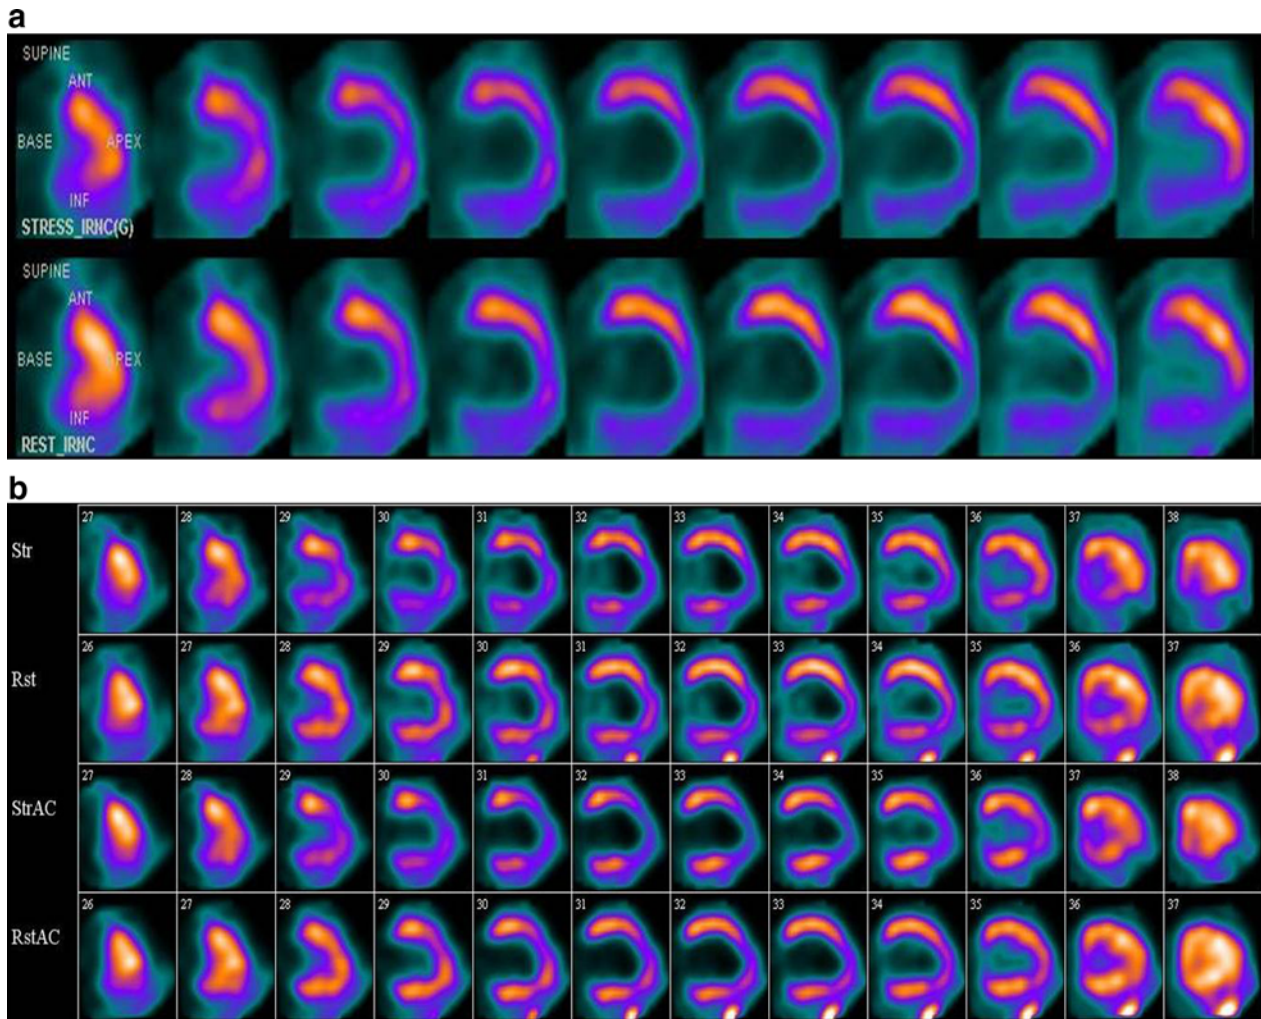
A Stress (*top row*) and rest (*bottom row*) supine SPECT was performed in this patient with an ischemic cardiomyopathy using a conventional dual-head NaI detector. In these vertical long axis tomograms the ventricle is markedly dilated, and there appear to be extensive, fixed perfusion abnormalities involving the apex and inferior wall. B The stress and rest (first and second rows, respectively) acquisitions were repeated on the Digirad X-ACT[®] camera with the patient sitting upright. There is partial resolution of the fixed inferior defect, indicating that with supine SPECT it was at least in part attributable to diaphragmatic attenuation. With additional AC (*third and fourth rows*) there is complete resolution of the inferior defect, indicating that with supine SPECT it was entirely attributable to diaphragmatic attenuation. There is also partial resolution of the resting apical defect, indicating some degree of stress-induced ischemia. Courtesy Gordon DePuey, St. Luke's-Roosevelt Hospital, New York, NY.
